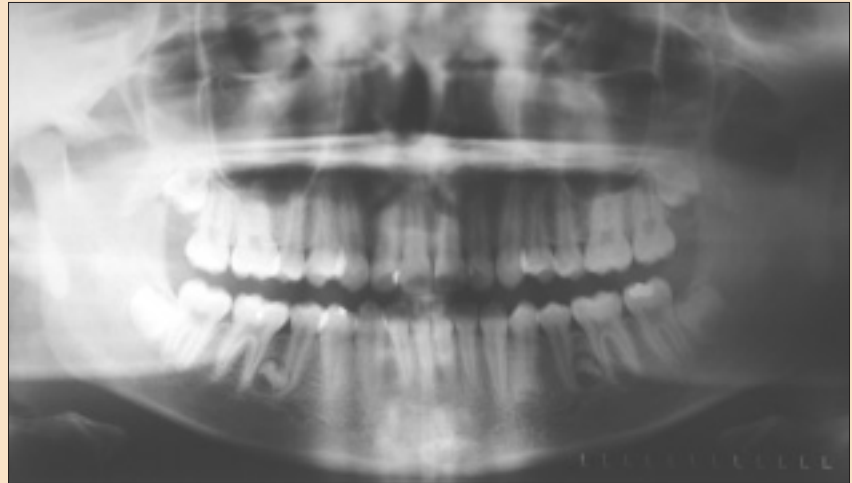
Orthopantomogram shows supernumerary premolars in quadrants 3 and 4.
